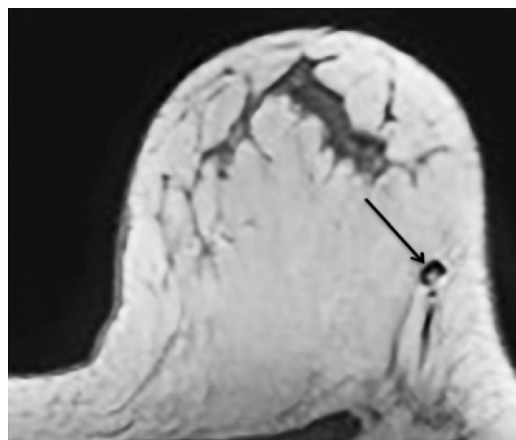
Intramammary lymph node. Axial nonenhanced T1-weighted MR image shows an intramammary lymph node (arrow), a finding characterized by a reniform shape and fatty hilum. Lymph nodes typically are hyperintense on T2-weighted images and are located adjacent to blood vessels.
